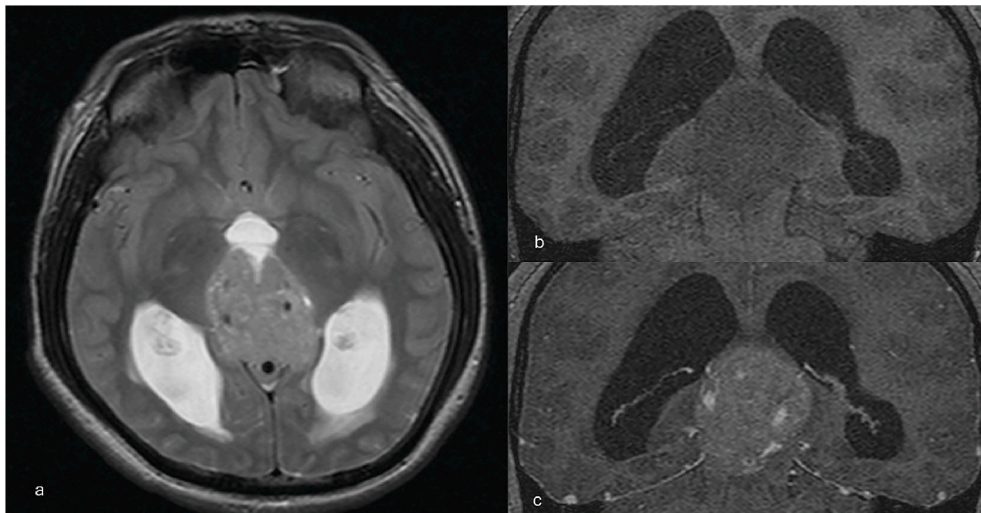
A 22-year-old male with a germinoma in the pineal region exhibits numerous tiny high signal intensity foci on the T2-weighted axial image (a). These tiny lesions display low T1 signal intensity (b) and do not enhance on the T1 post-contrast image (c), indicating cystic components. All the cystic components are smaller than 1 cm, so we categorize this tumor as a small cystic tumor.
